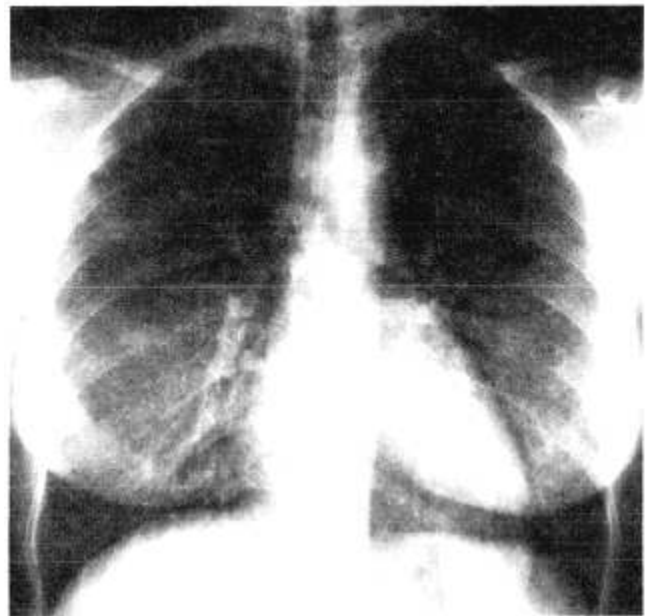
Chest roentgenogram of patient 2, 25 days following lavage of right lung and 18 days following lavage of left lung. Almost complete clearing of the diffuse bilateral infiltrates has occurred.
